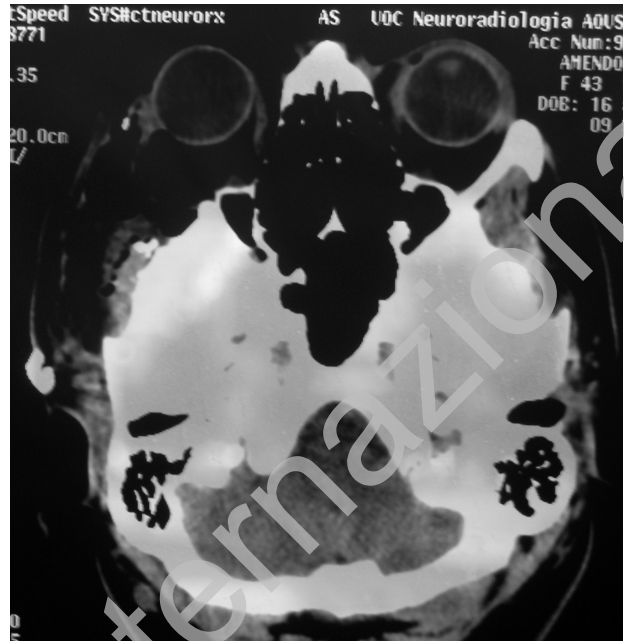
The postoperative axial image of the CT scan shows complete tumor excision.
